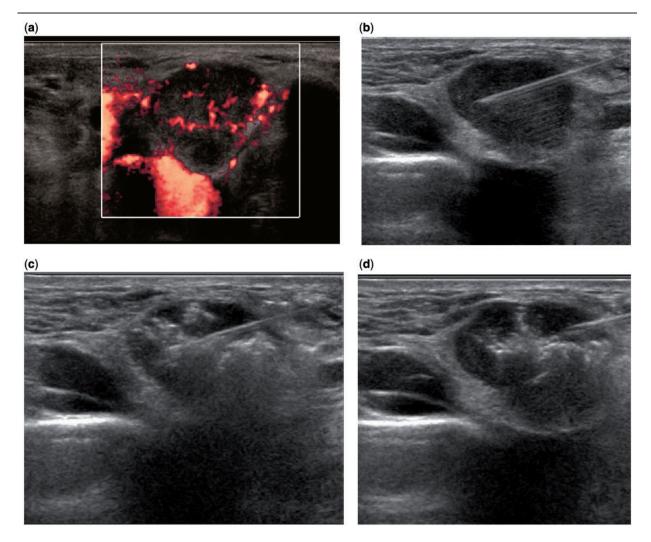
(A) Power Doppler ultrasound shows a metastatic node from papillary thyroid carcinoma with prominent vascularity. (B) The needle is first positioned at the deepest part of the metastatic node. (C) Ethanol injected into the metastatic node appears echogenic. (D) The needle tip is repositioned at another site for further injection until the entire node is adequately treated.
